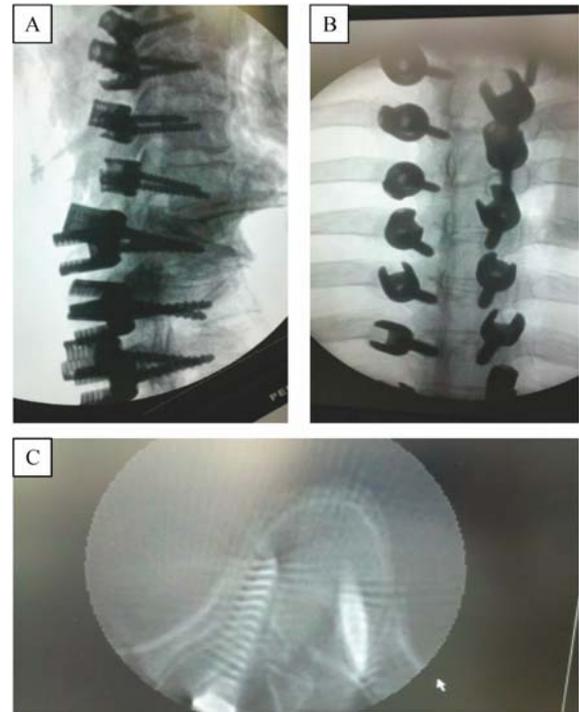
The pedicle screws in the three-dimensional C arm. A: Lateral X-ray film after screw placement; B: frontal X-ray film after screw placement; C: transect X-ray film after screw placement.
